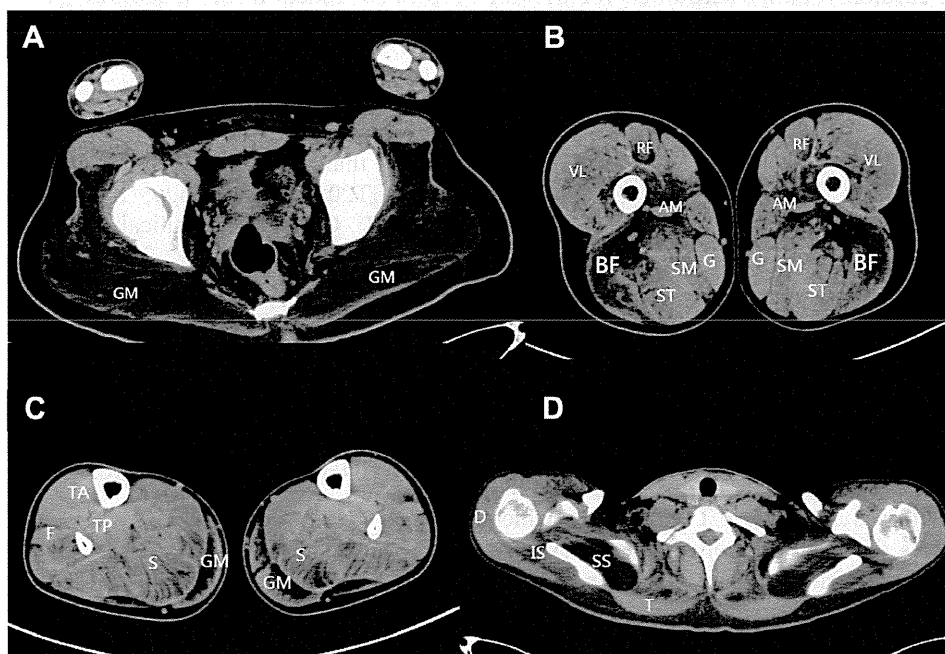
Muscle CT on Patient 2. Gluteus maximus muscles were severely affected (A), followed by biceps femoris and adductors (B). At the calf level, gastrocnemius and soleus muscles were severely involved (C). In the upper extremities, involvement of subscapularis, infraspinatus and supraspinatus were more severe than trapezium and deltoid (D). (D: deltoid; IS: infraspinatus; SC: subscapularis; BF: biceps femoris; ST: semitendinosus; SM: semimembranosus; S: soleus; F: fibularis; G: gastrocnemius; GM: gluteus maximus; RF: rectus femoris; VL: vastus lateralis; AM: adductor magus; G: gracilis).
